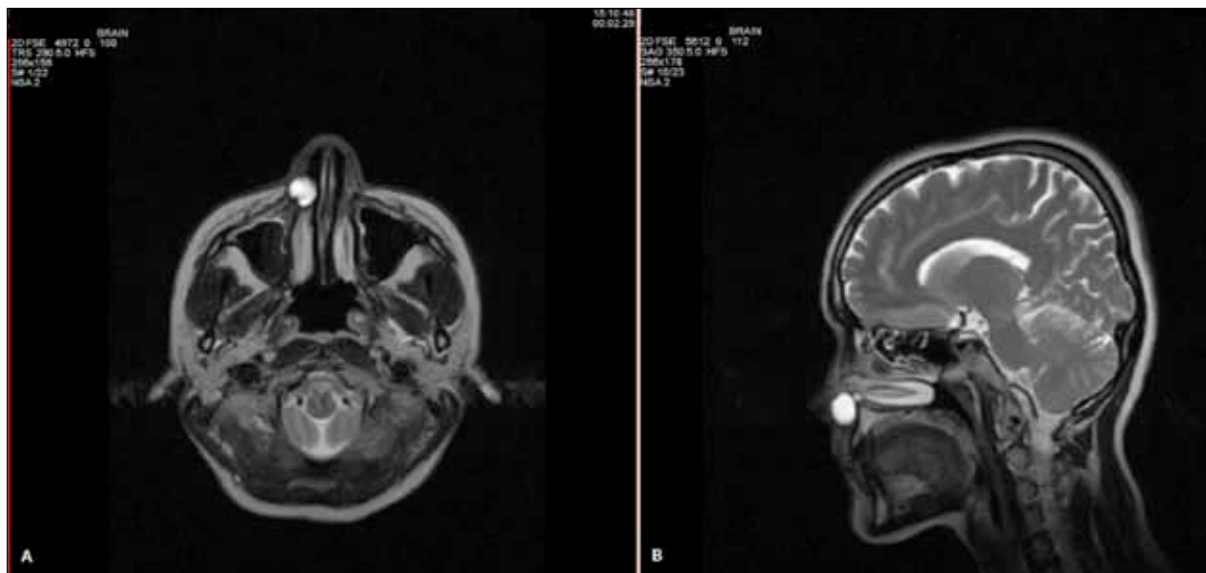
Cranio-facial MRI, axial (A) and sagittal (B) slices, shows a well-demarcated, rounded, homogeneous, low-density soft tissue lesion in the nasolabial region.
